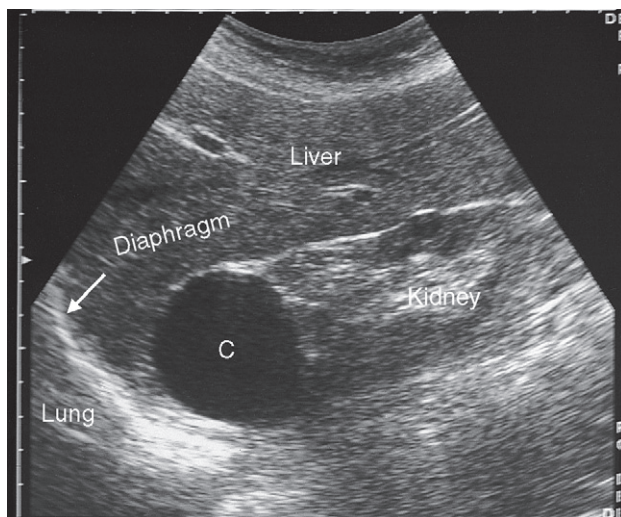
Ultrasound scan of longitudinal section through the liver and right kidney. A cyst (C) is present in the upper pole of the kidney.
